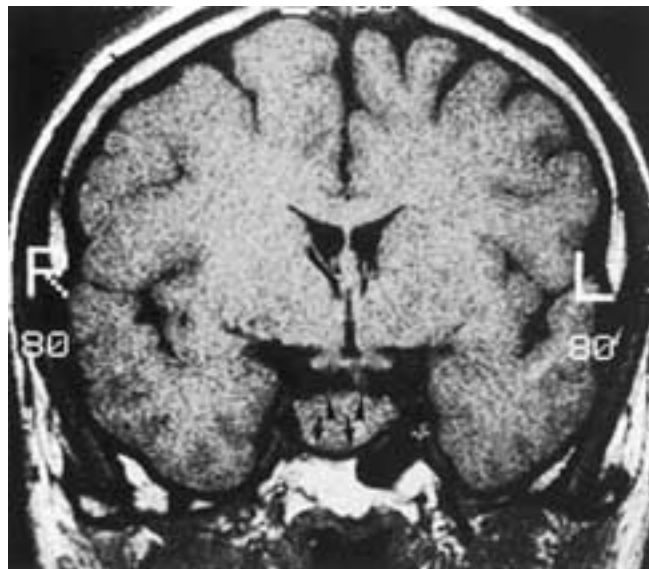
Pituitary adenoma. Coronal T1-weighted image shows downward bowing of an enlarged sella (*arrows*), upward convexity of the gland (*arrowheads*), and displacement of the infundibular stalk to the left.
